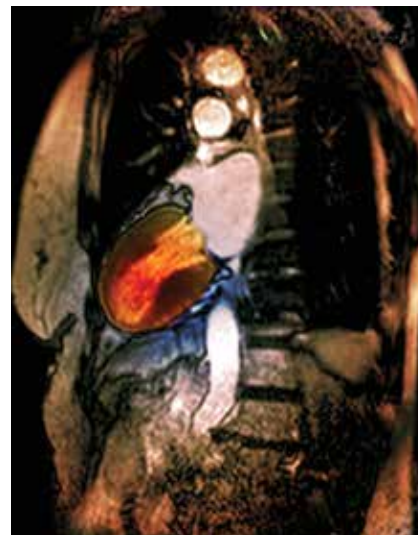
MRI of the heart (left anterior oblique view after contrast injection) showing Takotsubo cardiomyopathy with transient ballooning of the left ventricle in a 77-year-old woman.
